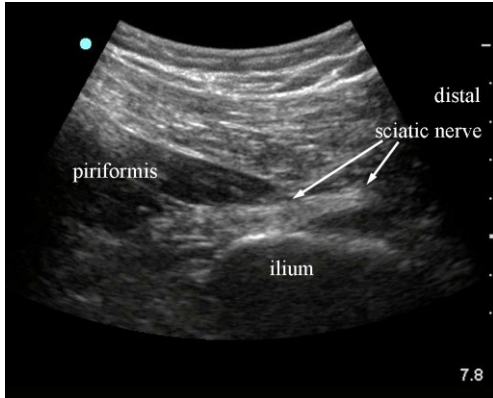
sonogram in plane of fig 3.31 showing sciatic nerve in long axis
